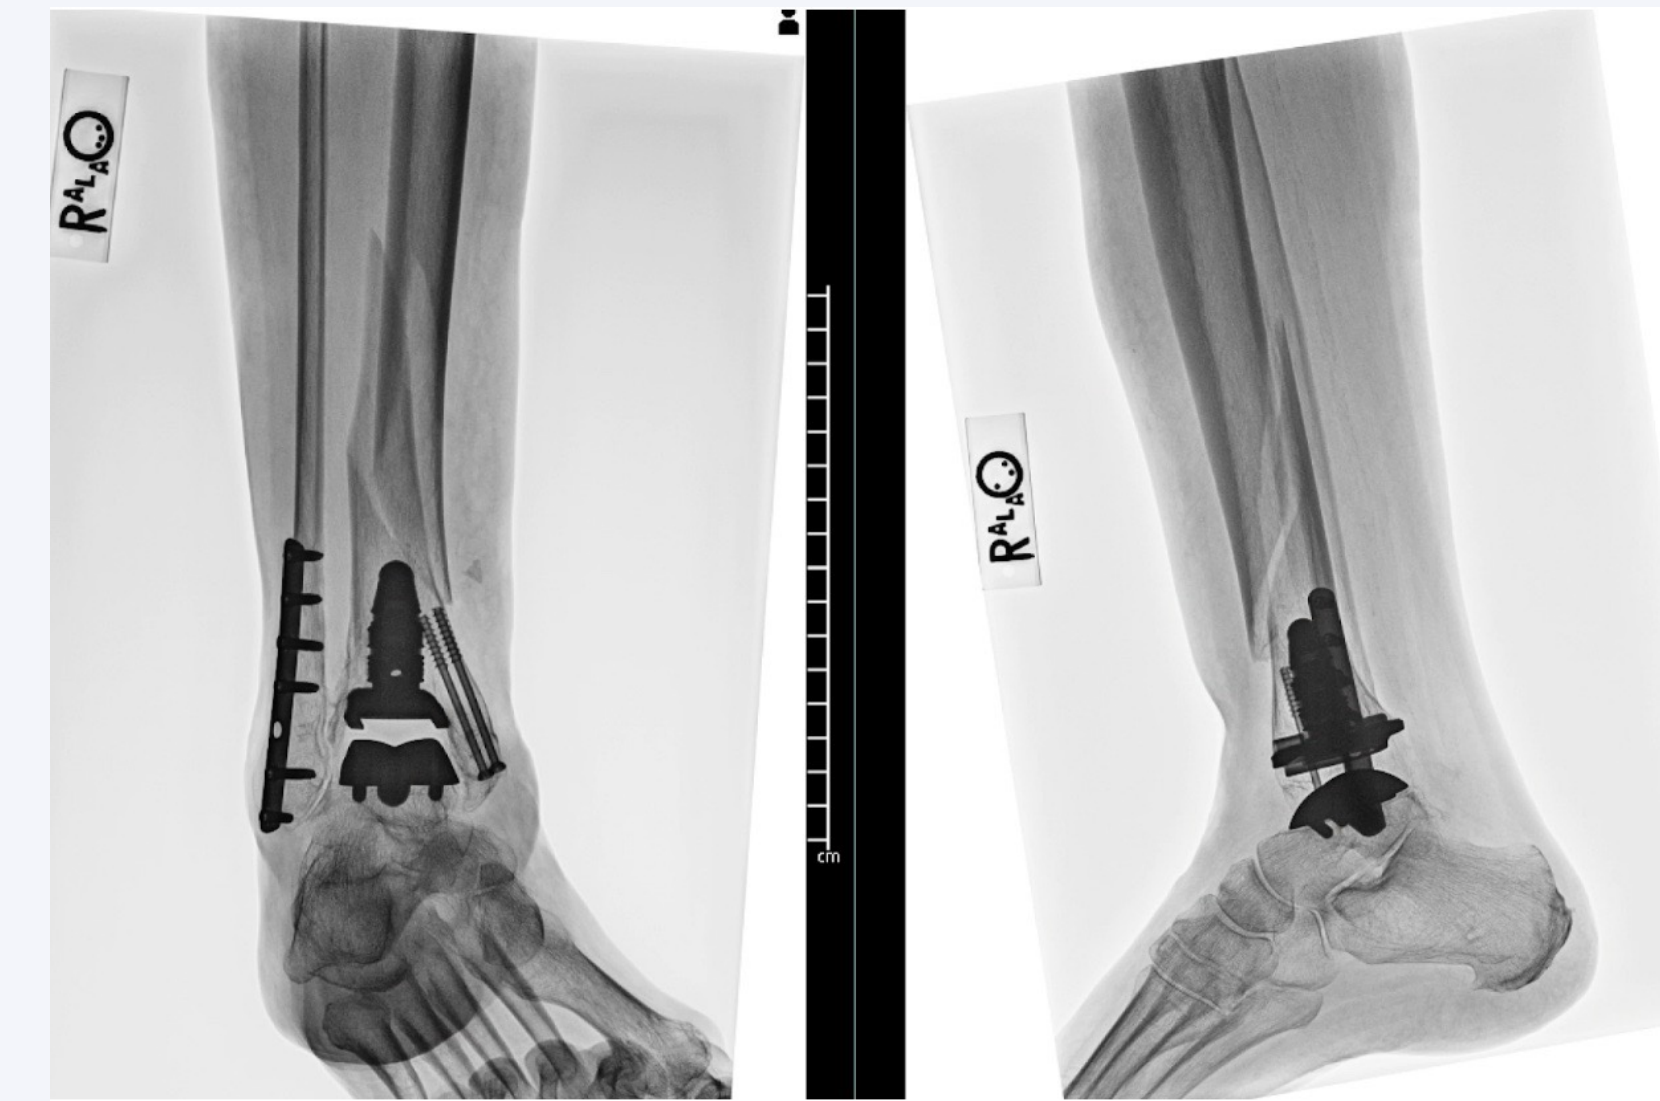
Patient 2 Anteroposterior (left) and lateral (right) radiographs of a 74-year-old female with a previous total ankle arthroplasty who presented following a fall and sustained a traumatic periprosthetic ankle fracture. The lateral and medial malleolar fixation was placed prior to the total ankle implant and fall. This represents a Hill-Brown Type B1 fracture as shown in Table 1.
